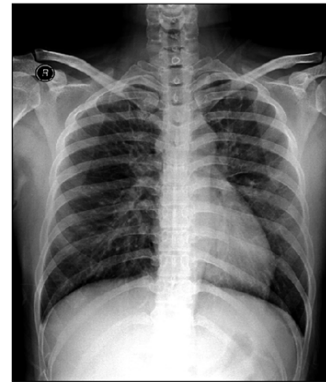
Chest radiograph of Case 1 with sub-clinical HAPO.
